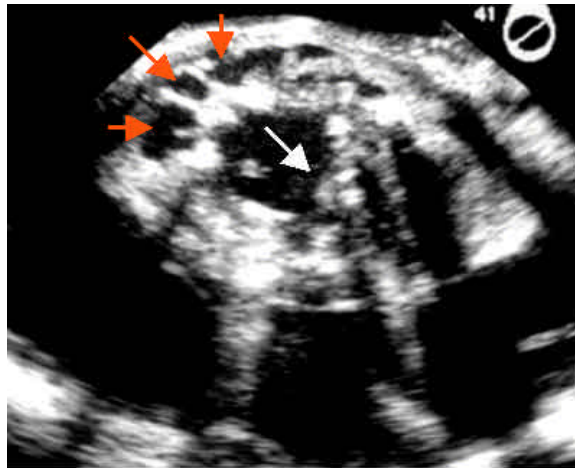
Transesophageal echocardiographic image of a mechanical prosthesis in aortic valve position demonstrating extensive tissue destruction and abscess formation (shown as echolucent pouches) in the perivalvular region (red arrows). Irregularly shaped infective vegetations are also present on the sewing ring and protrude into the prosthetic orifice (white arrow).
